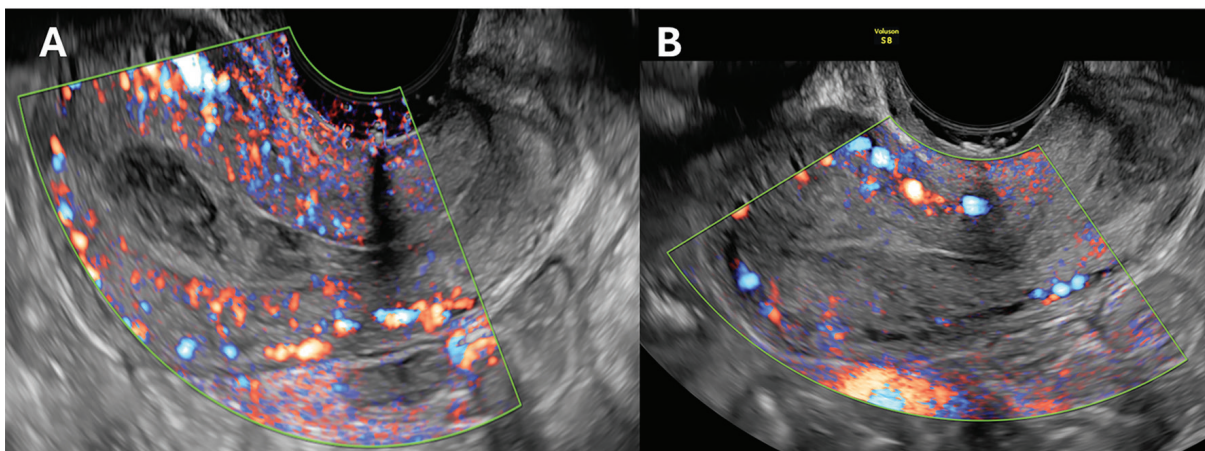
A) Follow-up Doppler ultrasound 3 weeks postoperatively confirmed sustained and complete resolution of the arteriovenous shunt but with a residual hematometra. Pulse repetition frequency 0.3 kHz. (B) Ultrasound 6 months postoperatively demonstrates absence of the hematometra and a sustained resolution of the arteriovenous shunt. Pulse Repetition Frequency 0.3 kHz.
